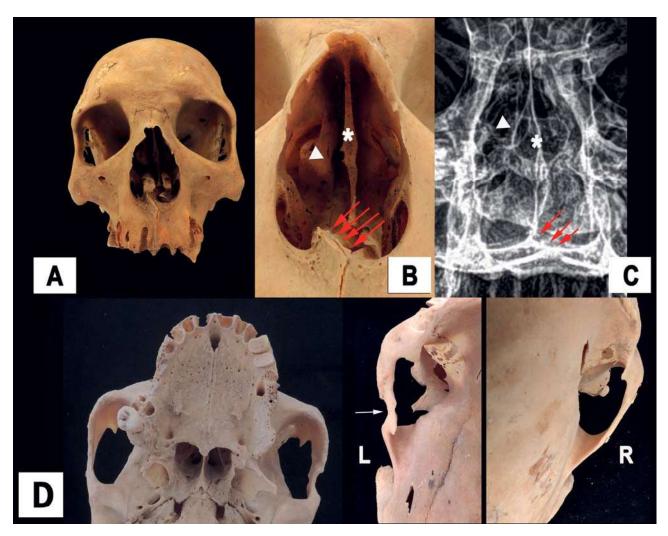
[TT12-UE 1188 SKULL 5713]. A, Skull – Frontal view. B, Detail of unilateral and bulbous *Concha Bullosa*. C, antero-posterior X-ray image of the nasal area. Deviation of the nasal spine, with a fracture callus (red arrows). Asymmetry of the nostrils. D, Inferior view: presence of a thrust fracture (white arrow) in the left zygomatic arch, with deflection of the bone fragment into the into the space towards the temporal fossa. White triangle shows the middle turbinates, asterisk the nasal septum.
